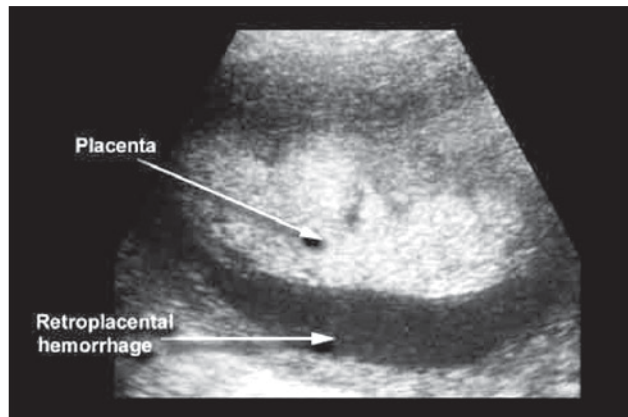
Sonogram of an abruptio placentae. Note the retroplacental hemorrhage. Image courtesy of Virlene Guzman, RDMS.
